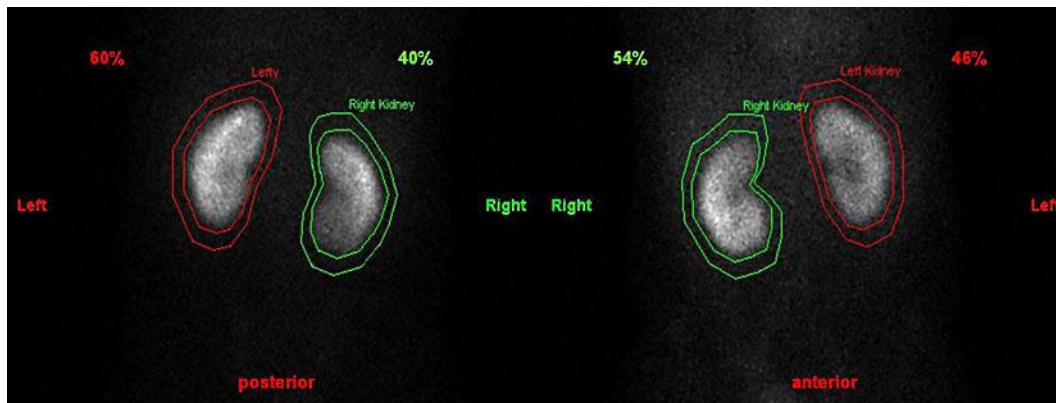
Posterior and anterior DMSA scintigraphy.
